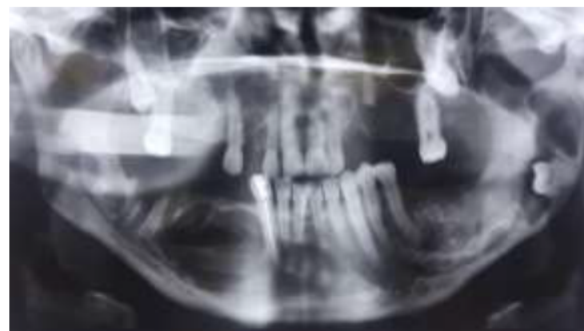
The radiographic view after the first marsupialization treatment on the right and left side.
